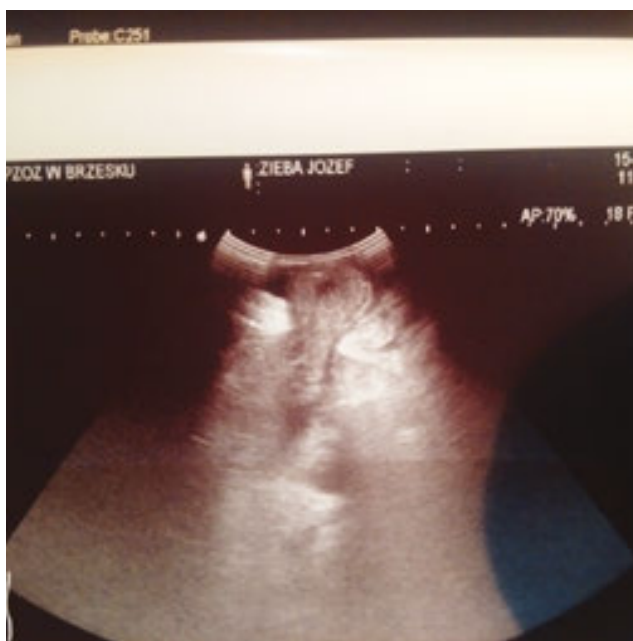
Ultrasonography revealing stomach incarceration.
